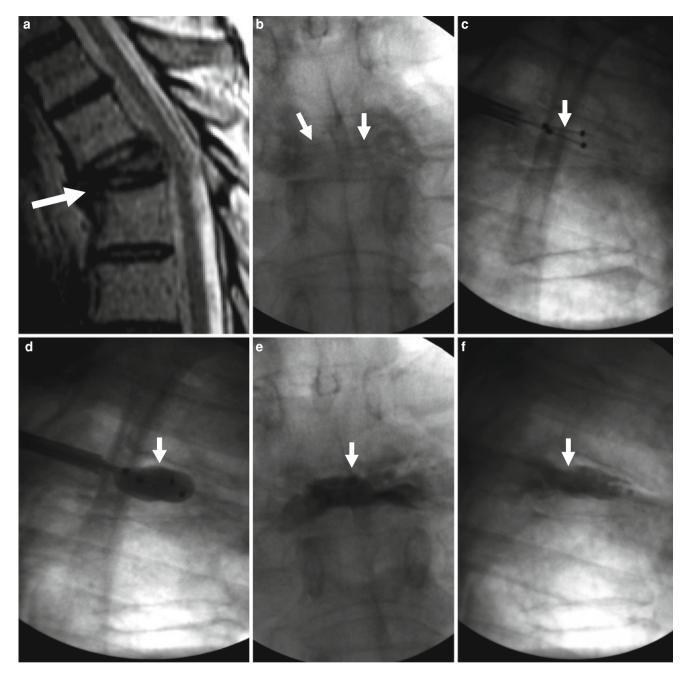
Kyphoplasty for painful T5 vertebra plana fracture in a 67year-old man with multiple myeloma. Excellent pain relief. a Sagittal T2 weighted MRI shows T5 fracture with severe anterior wedging and height loss (*arrow*) in a vertebra plana pattern. b X-ray, anteroposterior view shows severe height loss of T5 (*arrows*). c X-ray, lateral
